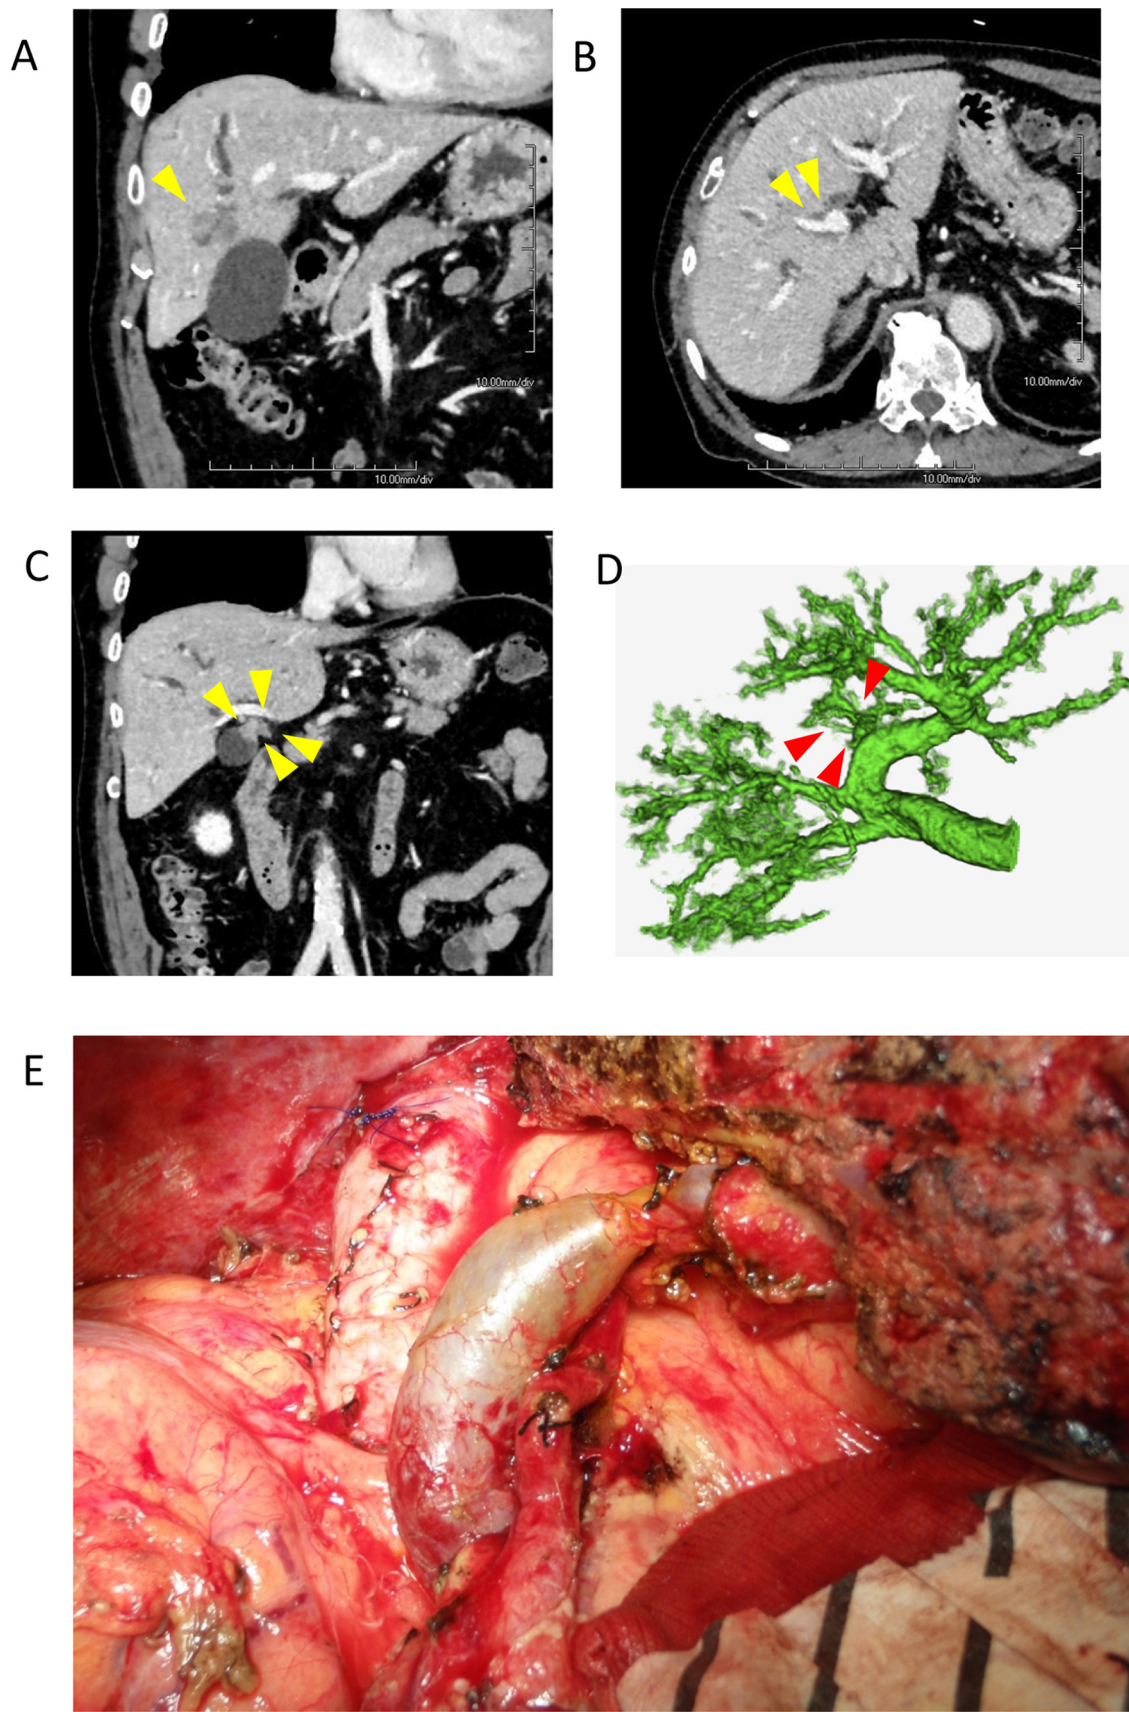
Preoperative CT imaging studies and the intraoperative photograph at the first operation in the case 1. (A) Arrow head shows the tumor located mainly in the anterior segment. (B) Arrow heads indicate the tumor extended to anterior branch of portal vein. (C) Arrow heads indicate the well-enhanced tumor occupied within the cystic duct. (D) Portal vein reconstruction using three-dimension CT scan shows anatomic variation of right posterior sectorial portal venous branch. Arrow heads indicate large caudate lobe branches. (E) intraoperative photograph representing the main trunk of portal vein following hepatectomy.
